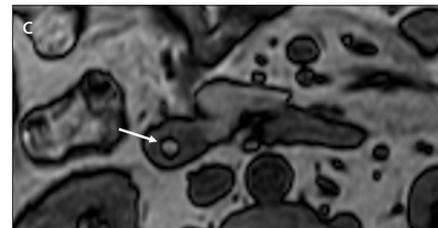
a–c. Duodenal lipomas in two different patients. Sagittal reconstructed contrast-enhanced CT image (a) shows a submucosal lesion (arrow) in duodenal bulb with negative Hounsfield values (-94 UH). On MRI, axial T1-weighted image (b) shows a hyperintense lesion (arrow), which demonstrates a surrounding chemical-shift artifact (arrow) in the out-of-phase T1-weighted image (c).
